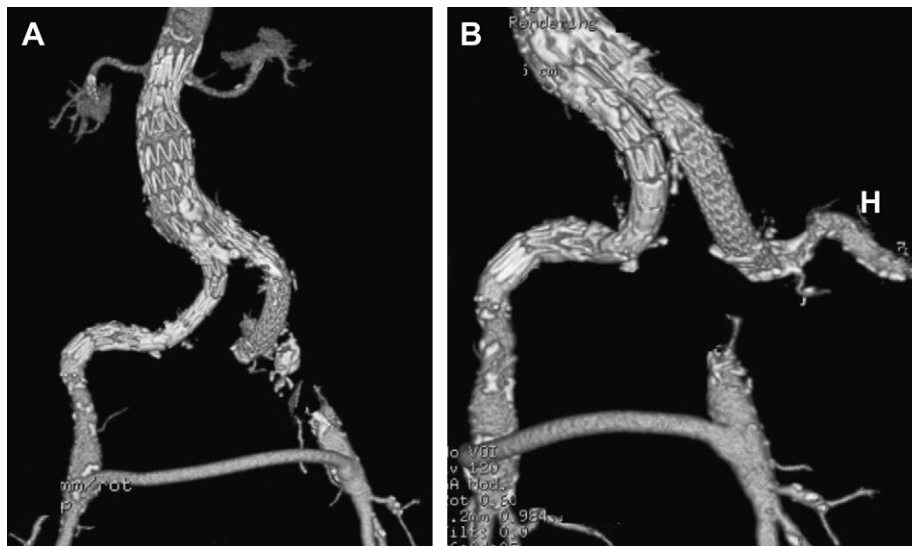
Volume rendering reconstructions of a postoperative computed tomography scan, showing complete sealing, patency of all reconstructions, and flow into the left hypogastric artery (H).
